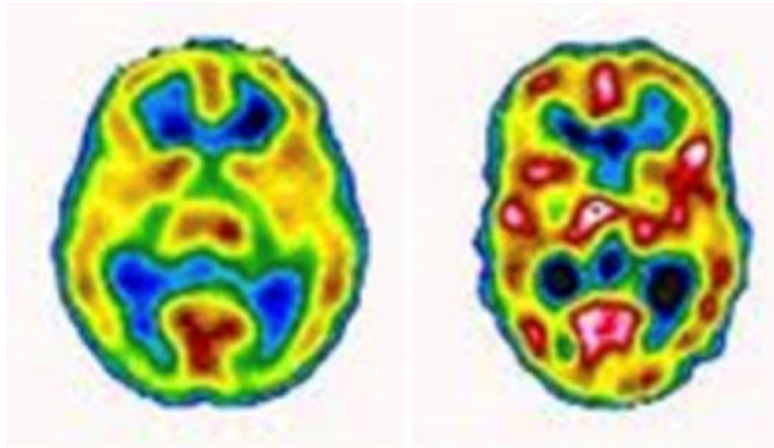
a) Normal (SPECT) b) Bipolar Affective Disorder
